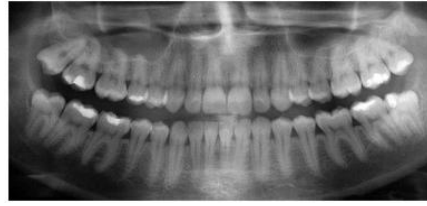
Cropped x-ray image
